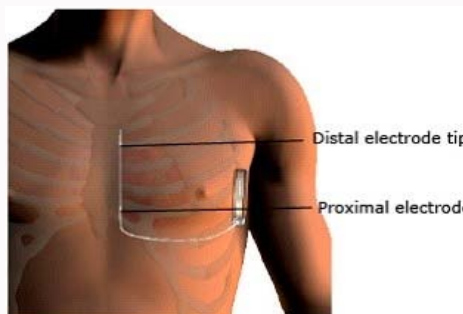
Image showing optimal placement of the S-ICD system, with the electrode tunneled from the pulse generator to the xiphoid process, and along the left parasternal border. Image reproduced with permission from Boston Scientific.
